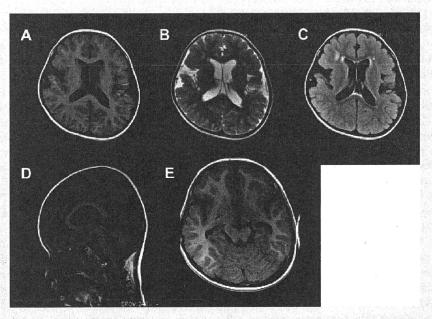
A—C: Brain MRI showed sporadic periventricular hyperintensity in a T2-weighted image, frontal lobe polymicrogyria; (D) cerebellar, brain stem hypoplasia, and (E) cerebellar cyst.
